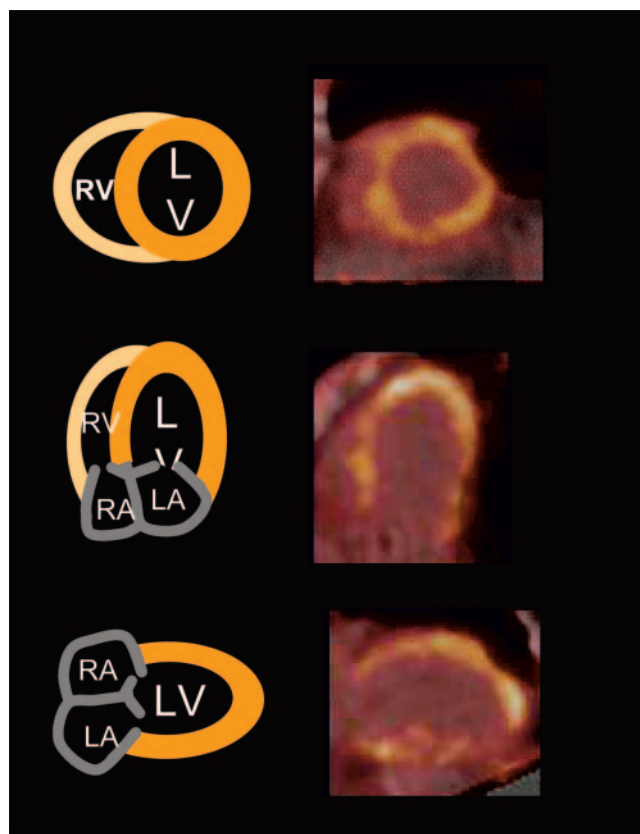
Example of PET images attenuation corrected by misaligned CT image with artifacts in anterolateral wall of left ventricle. Artifacts resulted from motion associated with deep breathing of patient during CT scan. Resulting AC map is misaligned with PET emission data. Incorrect AC results in artifactual defects most commonly in anterolateral wall. LA = left atrium; LV = left ventricle; RA = right atrium; RV = right ventricle.
